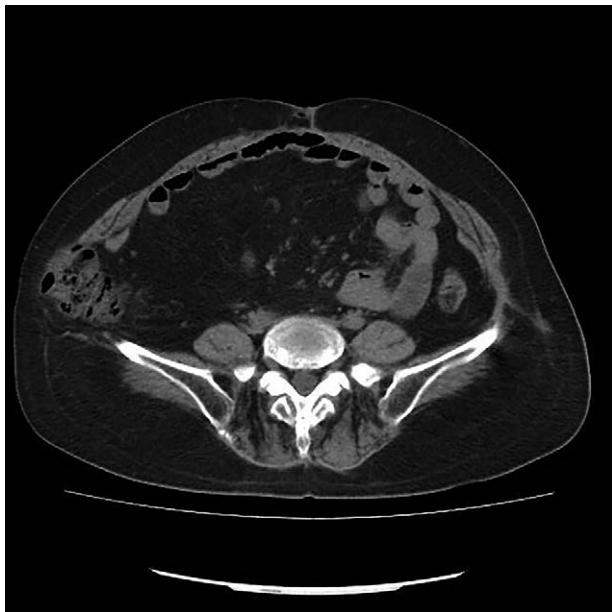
Abdominal computed tomography 1 year after the initial trauma showing a traumatic abdominal wall hernia above the right iliac crest, with internal organ herniation through the defect.
